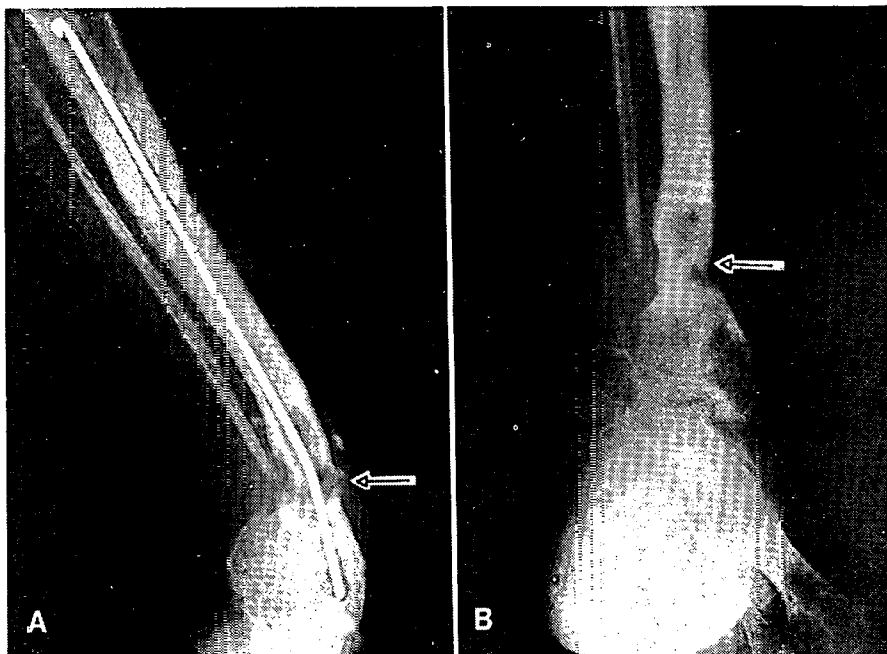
(A) X-ray taken prior to the application of electric current. There is a rather prominent pseudarthrosis defect (arrow) with angulation. (B) X-ray taken 4 months after continuous application of 4 μ a of current. The healing site (arrow) is being replaced by bone.
